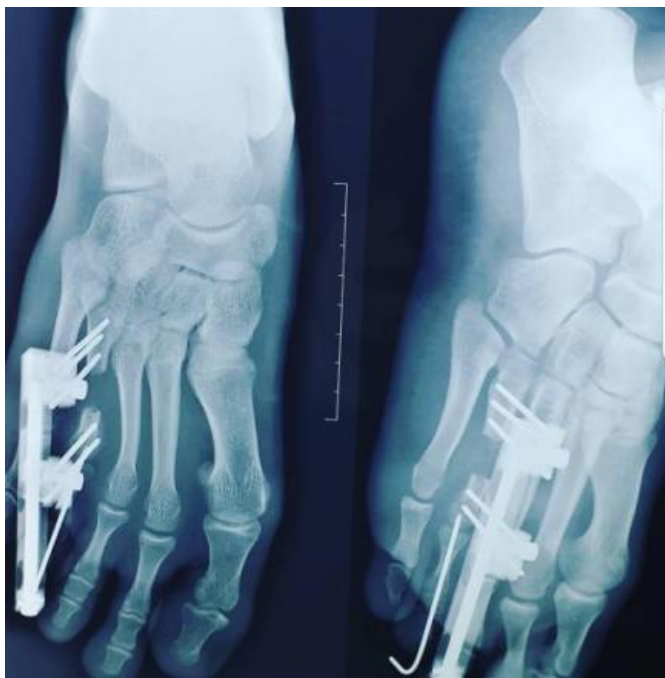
Radiograph of the foot at 4 weeks after surgery
